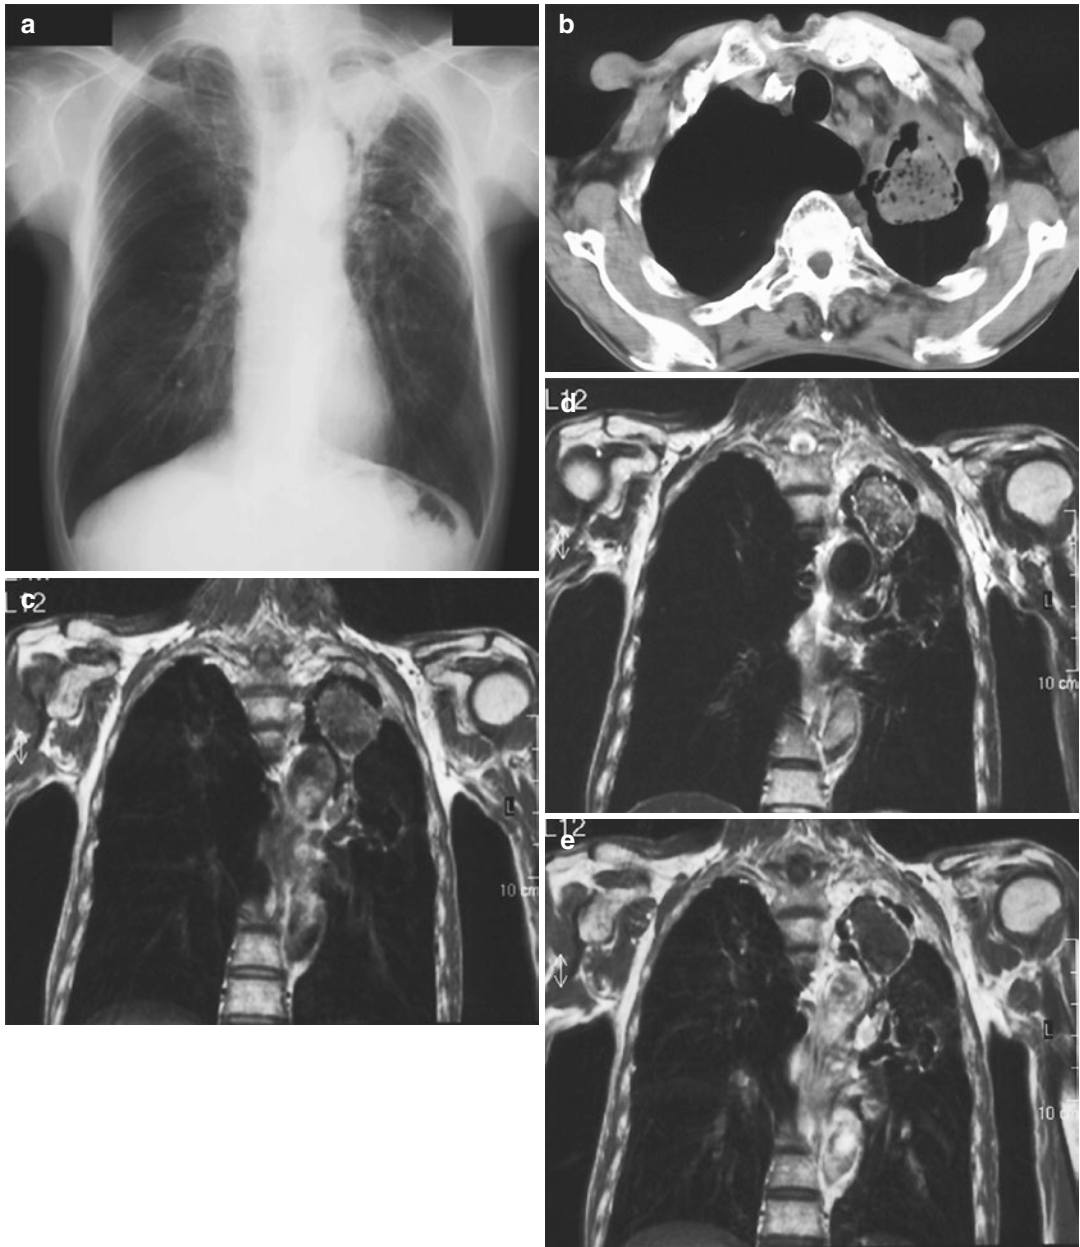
A 60-year-old male with aspergilloma in the left upper lobe. Chest radiograph (a) shows “air crescent” sign in the left upper lung field. Conventional CT (b) shows fungus ball within cavity. Conventional T1-weighted SE (c) and T2-weighted turbo SE (d) images on coronal plane
